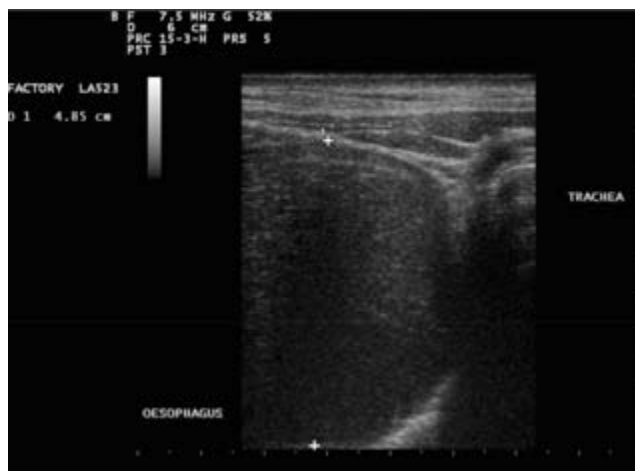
Ultrasonogram taken from the ventral aspect of the cranial cervical region. The cyst is on the left side of the image and has been demarcated between the 2 crosses and measured. The trachea is on the right side of the image.
